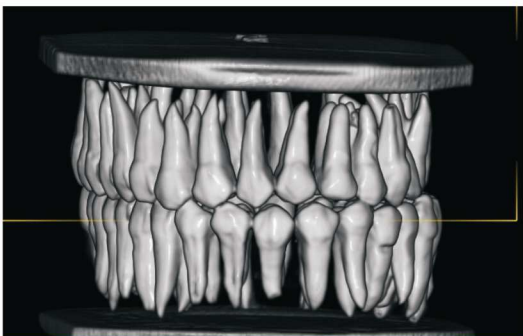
Sample block for CBCT imaging
